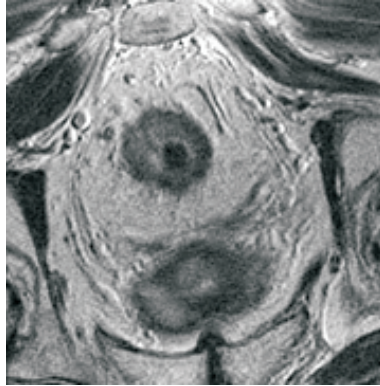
One slice of a 3-dimensional (3D) colorectal MR image after preprocessing done to remove bias field. Notice the residual bias field in the upper part of the image and a complex heterogeneous nature of the central part of the image.
